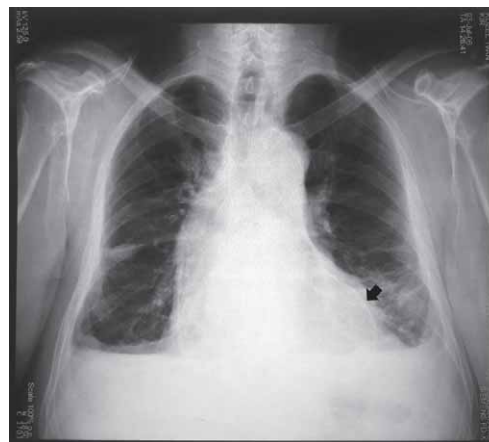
Chest X-ray (AP) showing contrast extralumination into pericardium (black arrow).
